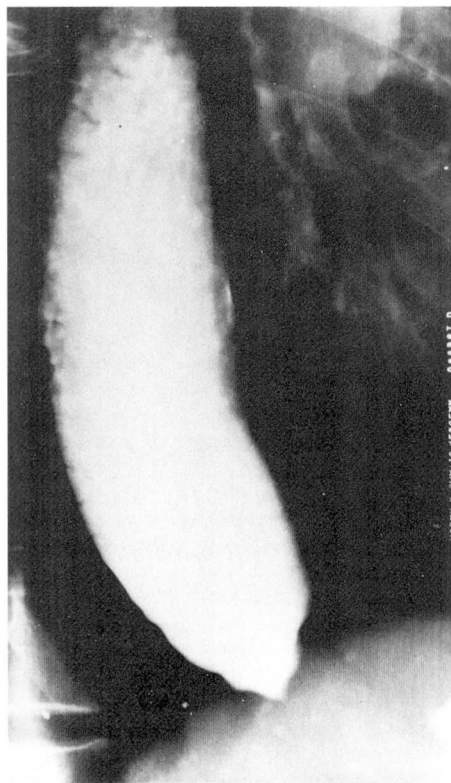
Barium meal showing a dilated esophagus with lengthening and tapering at the distal end (case 2). Roentgenographic diagnosis was achalasia.
